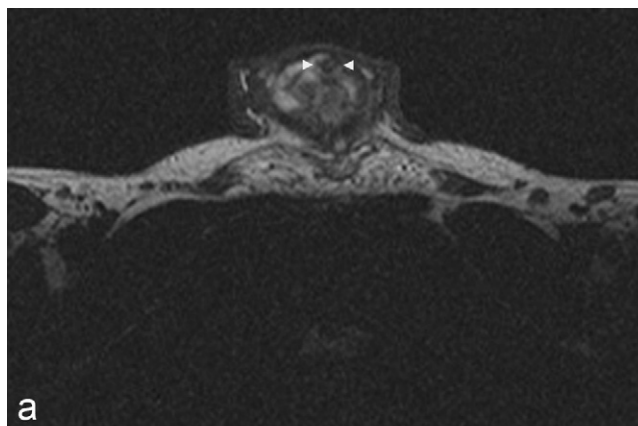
Transverse (a) and sagittal (b) T2-weighted images showing an inhomogeneous mass with low signal intensity disrupting both cavernous corpora and compressing the corpus spongiosum and urethra (arrowheads).
